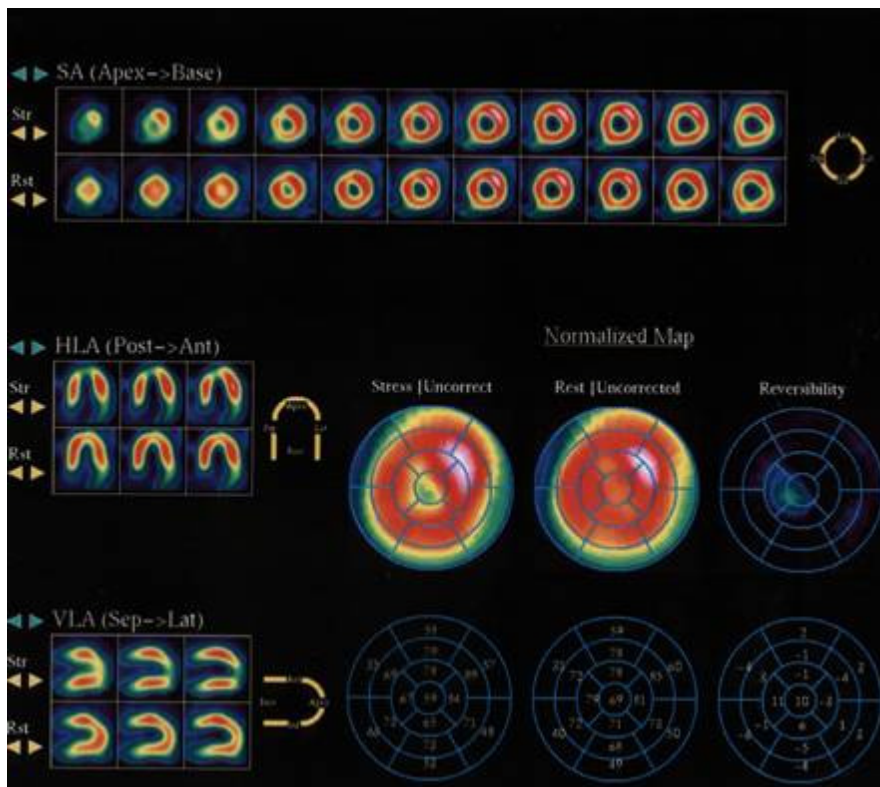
SPECT image of a typical patient before treatment. Reversible ischemia can be observed in the apical zone
